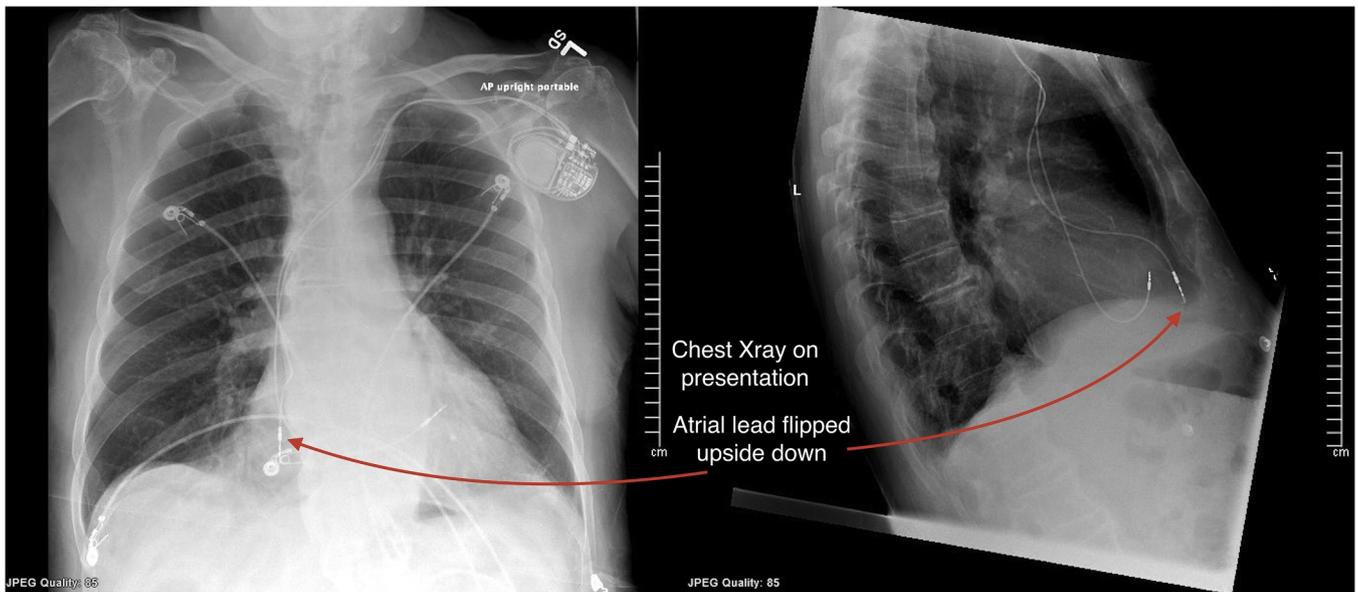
Chest X-ray 2 views upon presentation showing the atrial lead upside down.
